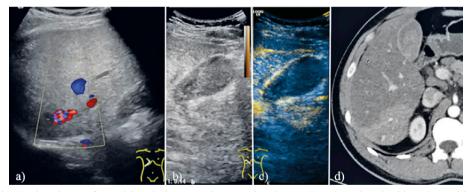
Hemobilia. Exploration performed in relation to an interventional procedure (transjugular biopsy) resulting in intrahepatic arteriovenous fistula communicating with the biliary ducts and hemobilia: a) color Doppler; b) grayscale; c) CEUS (excludes active bleeding); d) CT exploration (arterial, transversal).
